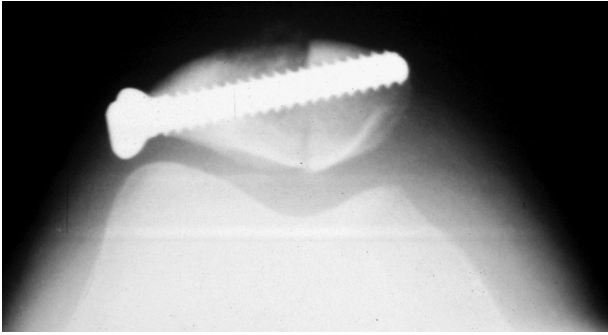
Radiograph showing fixation of an intraoperative patella fracture.
